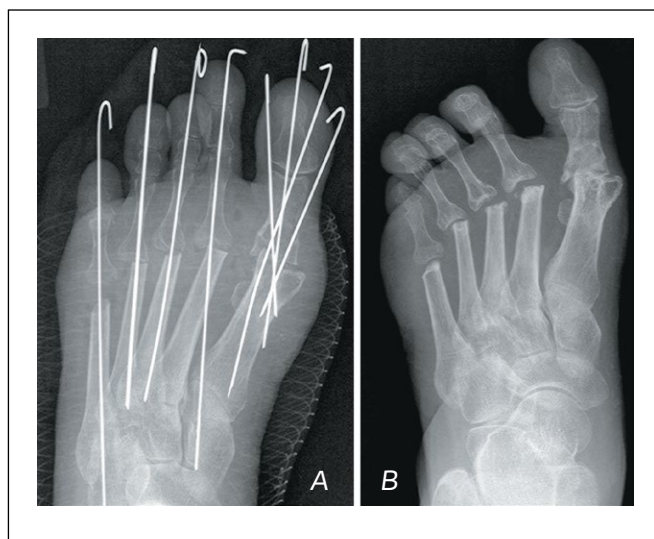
A – postoperative X-ray; B – X-ray 8 weeks after GRS (false joint 1 MTP).
